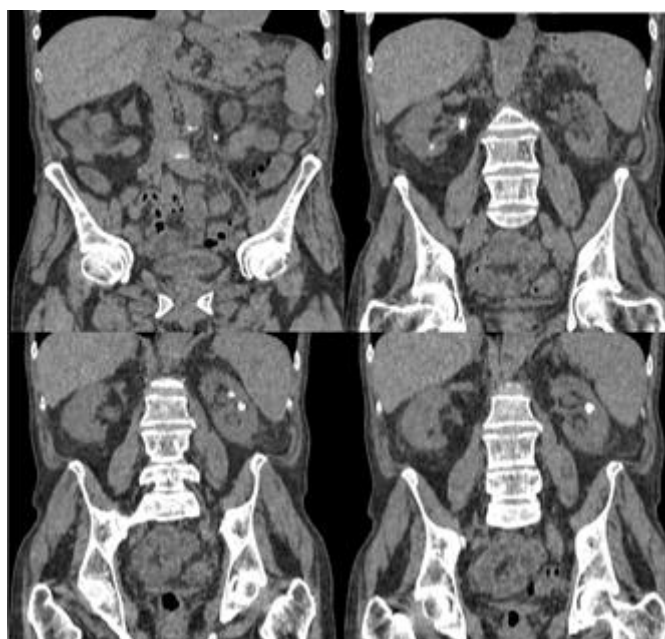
CT image revealing the bilateral nephrolithiasis and an associated obstructive left ureteral calculus.
